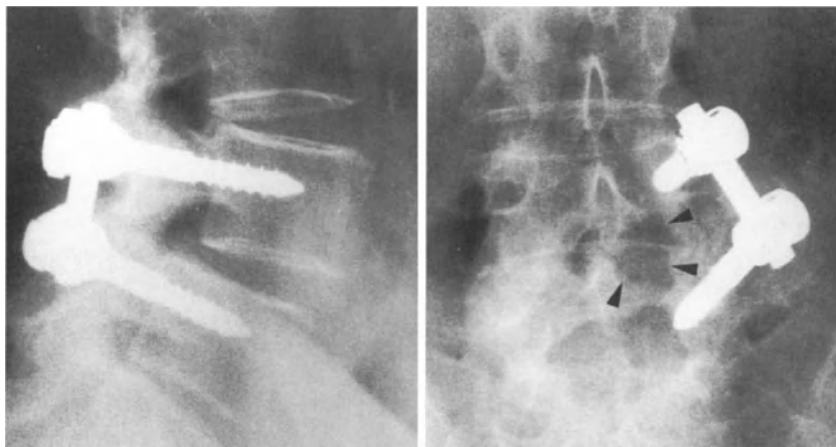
Postoperative radiographs of a patient with stenosis of the spinal canal caused by degenerative spondylolisthesis of L4. Central laminectomy (arrowheads) was performed along with bilateral intertransverse instrumented fusion.
